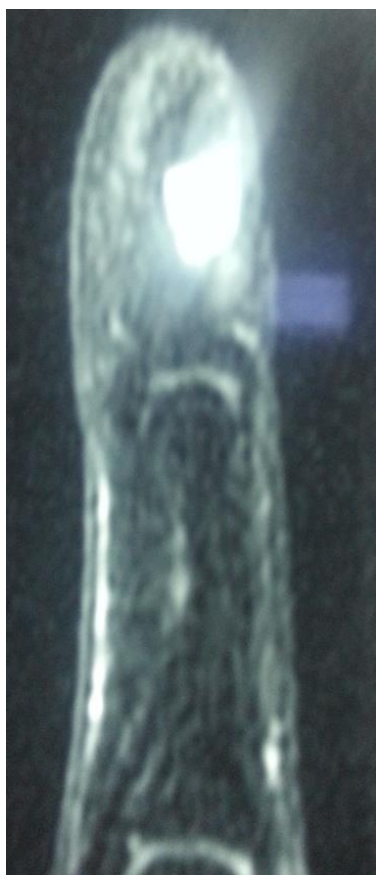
MRI pictures of glomus tumour of finger tip.
